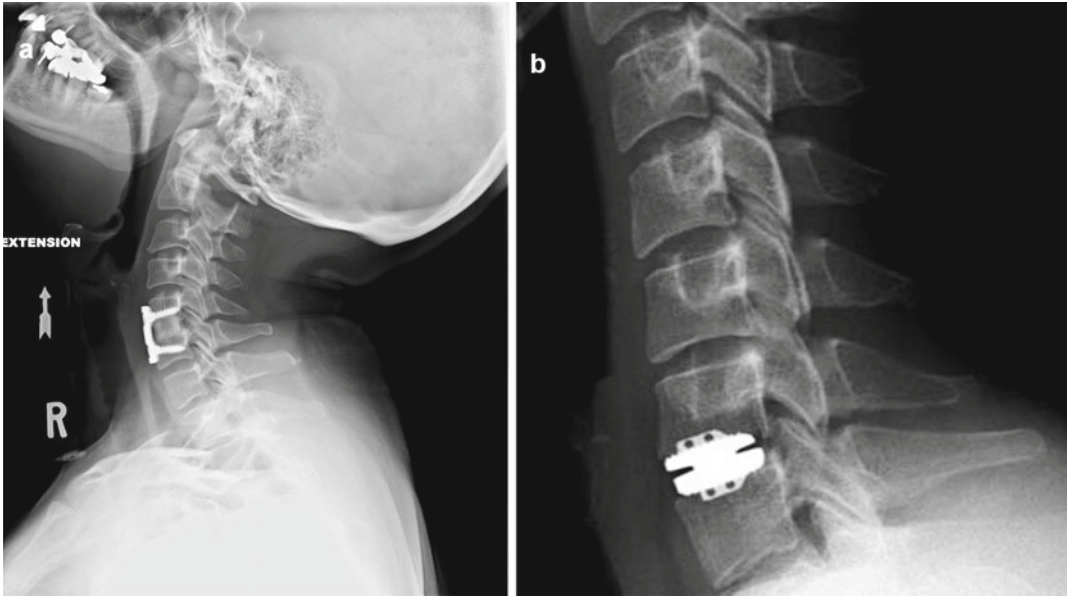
(a, b) Lateral radiographs after anterior cervical discectomy and fusion (a) and cervical disk replacement (b) for soft disk herniation
